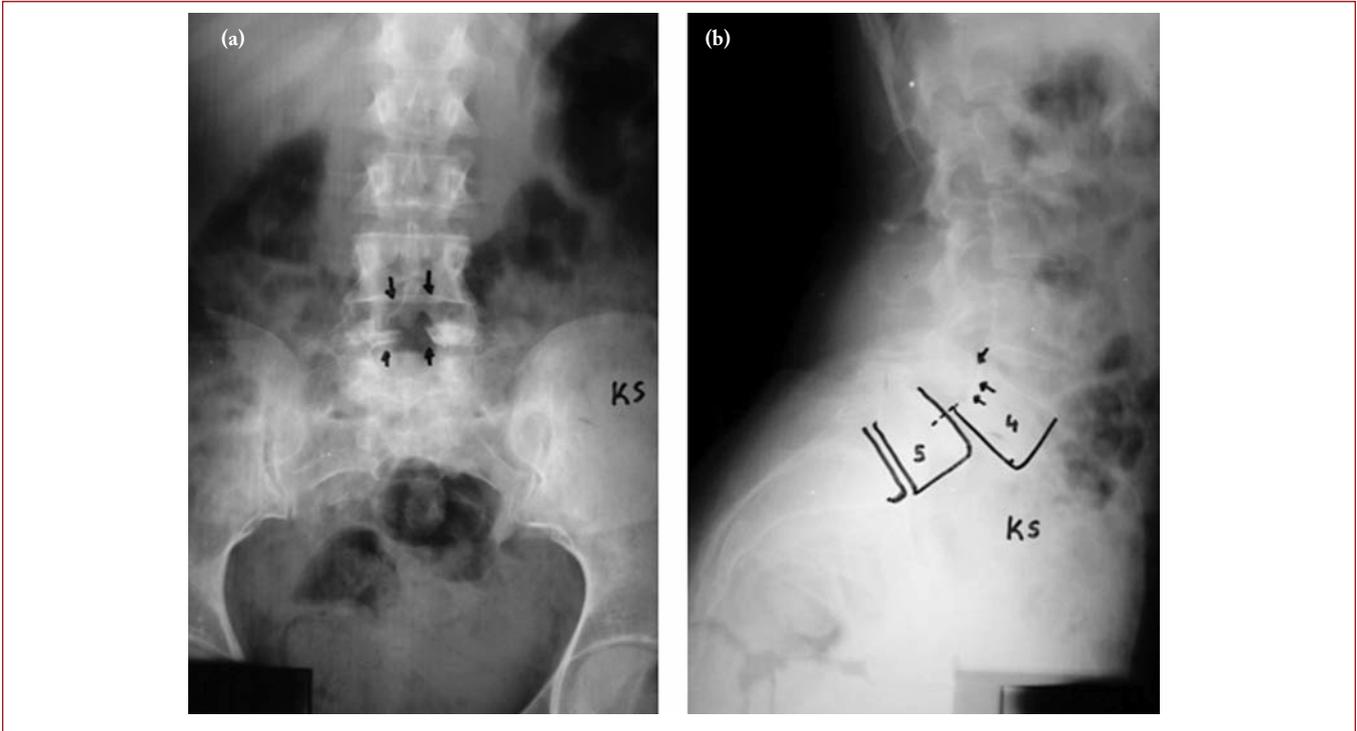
A 42-year-old female patient (K.S.). a. Anteroposterior lumbosacral X-ray showing occult spina bifida at the L5 level, b. Lateral lumbosacral X-ray showing 50% spondylolisthesis.
